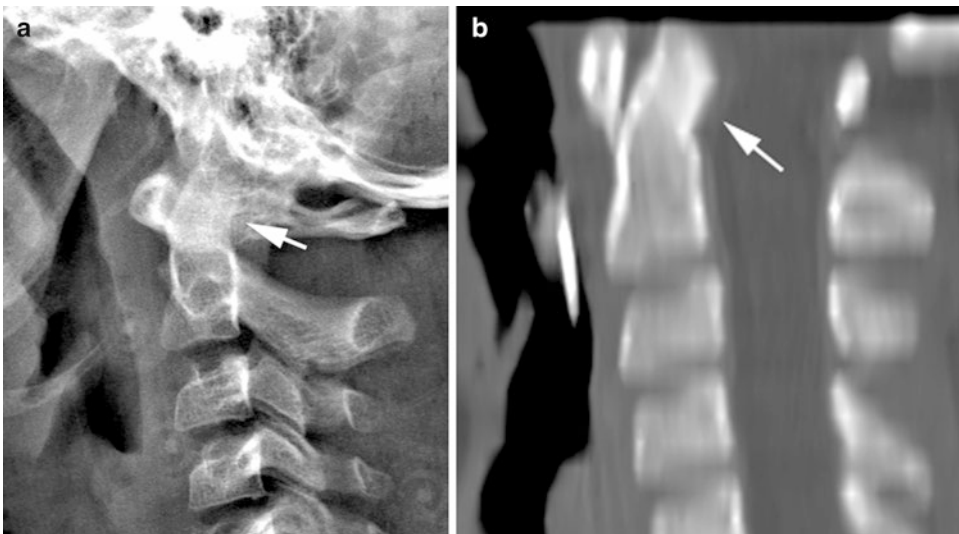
(a, b) Posteriorly tilted dens: normal finding. (a) Note the posteriorly tilted dens (D). This patient was normal. (b) CT study, sagittal reconstruction. Note the posteriorly tilted dens (arrow) (From *Imaging of the Cervical*
